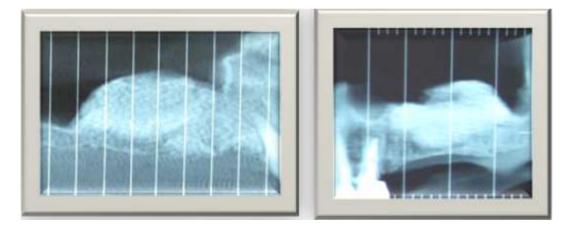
Post surgery radiography after 6 months
